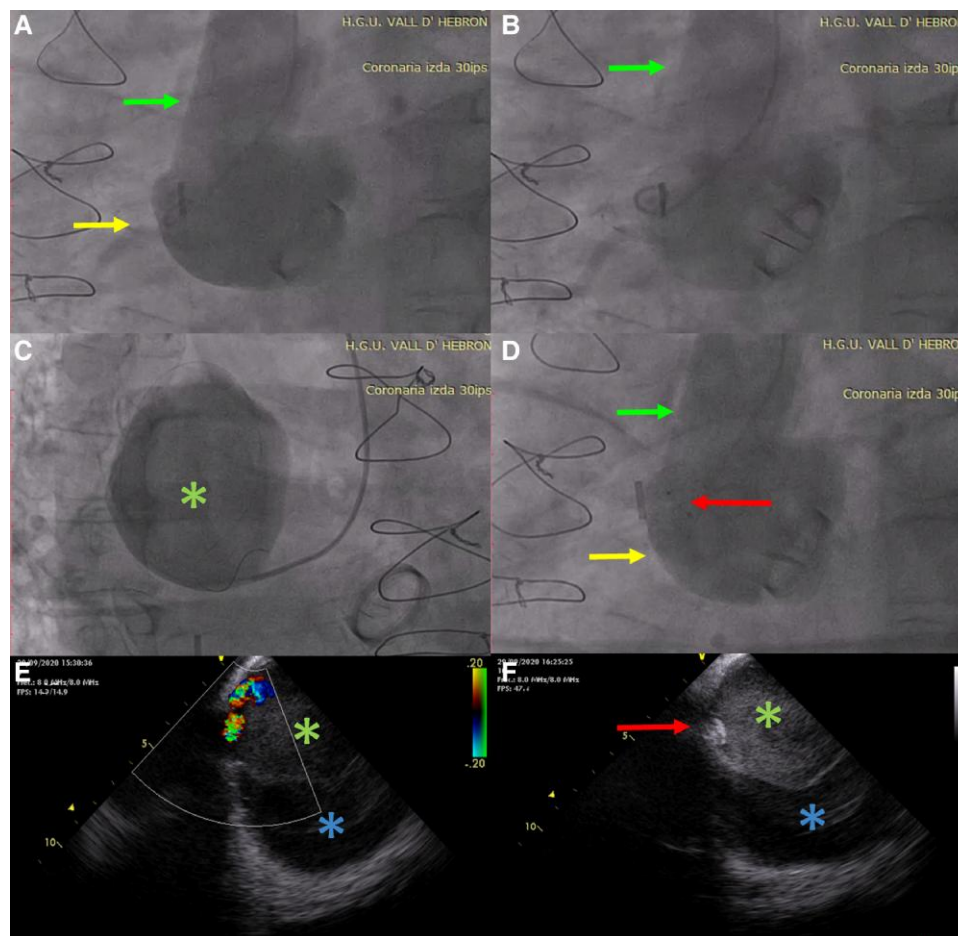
Angiography and ICE. Left anterior oblique (LAO) (A, B, D) and right anterior oblique (RAO) views showing a dilatated aortic root (arrows) and distorted aortic tube (arrows). Image (C) shows selective catheterization of the large pseudoaneurysm with contrast filling (asterisks). ICE (E, F) shows colour Doppler flow with Coanda effect into the pseudoaneurysm, compressing the aortic lumen (asterisks) with thrombosis after its closure. In image F, ADO II dispositive is shown (arrow).
